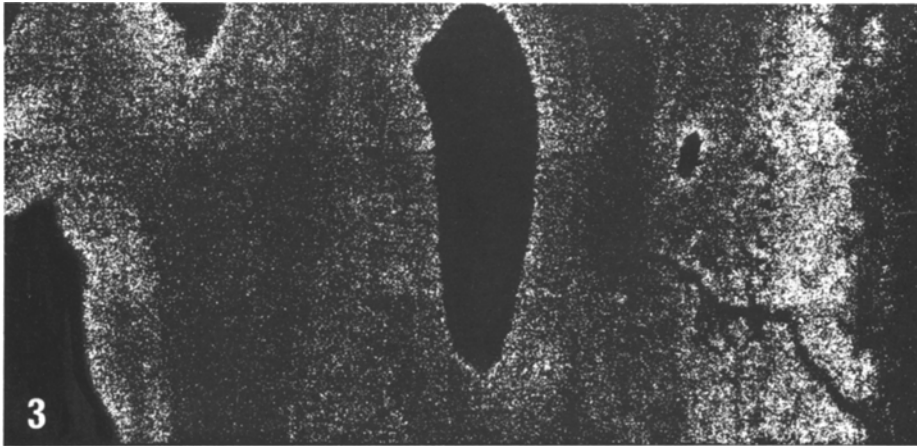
F K α X-ray images of an iliac crest biopsy taken from a fluorotic subject, It can be seen that the fluoride is not evenly distributed. $\times 70$
